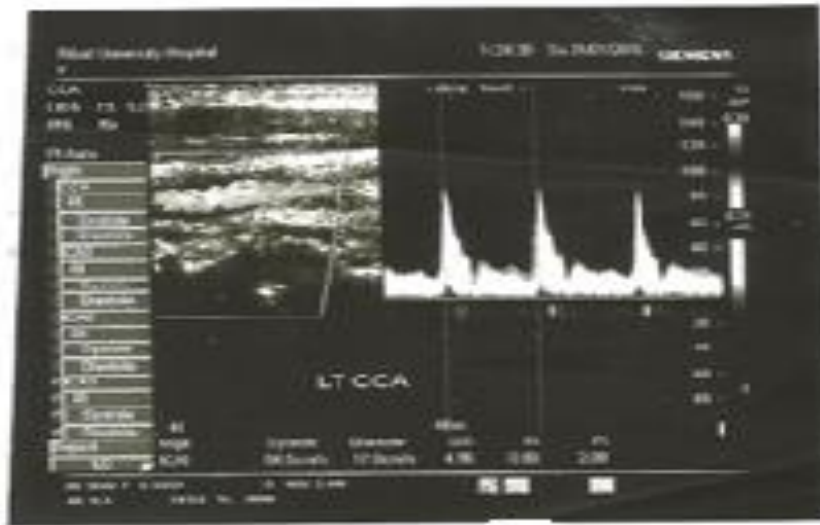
Lt CCA- male- 45 years diabetic patient normal Doppler parameters.
